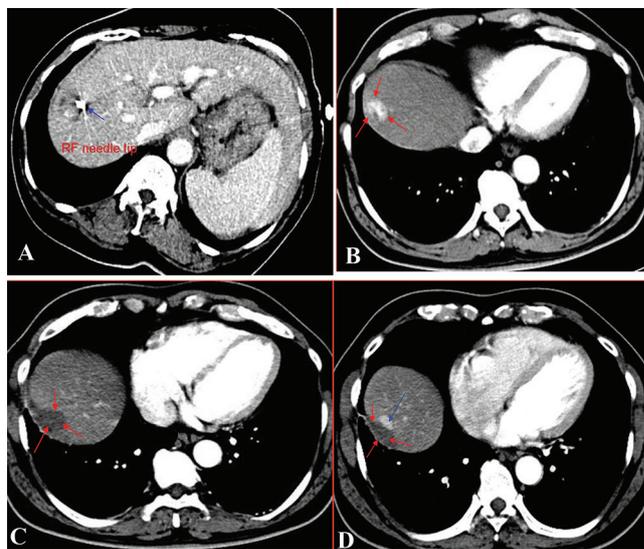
A. Case 4-CECT of a 69 year old patient with small HCC in the right lobe- planned for RFA. The Radiofrequency ablation needle tip is placed in the outer aspect of the lesion under CT guidance. B. Case 20- 64 year old male with chronic liver disease – before and after Radiofrequency ablation of small HCC. Small enhancing lesion in arterial phase in segment 8 (subdiaphragmatic surface). C. Post-contrast scan arterial phase 1 month after RFA of the lesion showing no enhancement consistent with total ablation of the lesion. D. Post-contrast scan arterial phase 3 months after the above scan showing nodular enhancement in the margin of the ablated lesion consistent with recurrence.
